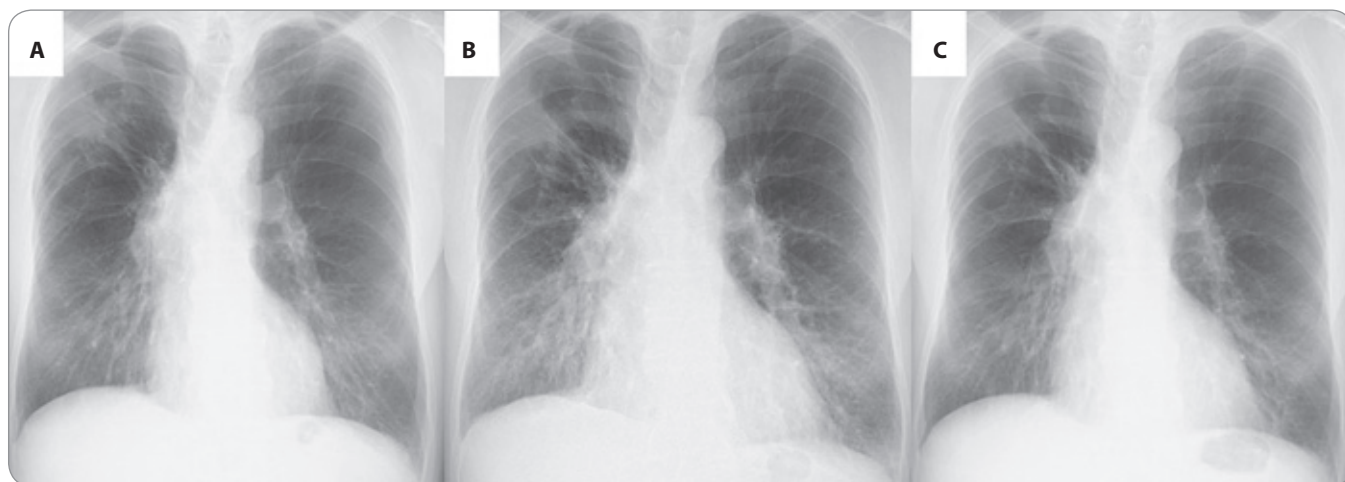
Plain X-ray film taken A) at re-administration of pembrolizumab; B) at one month later; C) after the treatment diuretics and beta-blocker. There was observed an increase in cardiac size and congestion, with later improvement of these findings.
